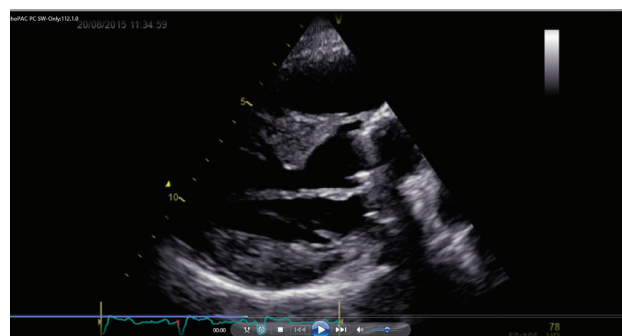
Echocardiography after coronary artery bypass grafting with dilatation of the aortic annulus, resection of the left ventricular outflow tract and implantation of the SJM Regent 21 valve.
